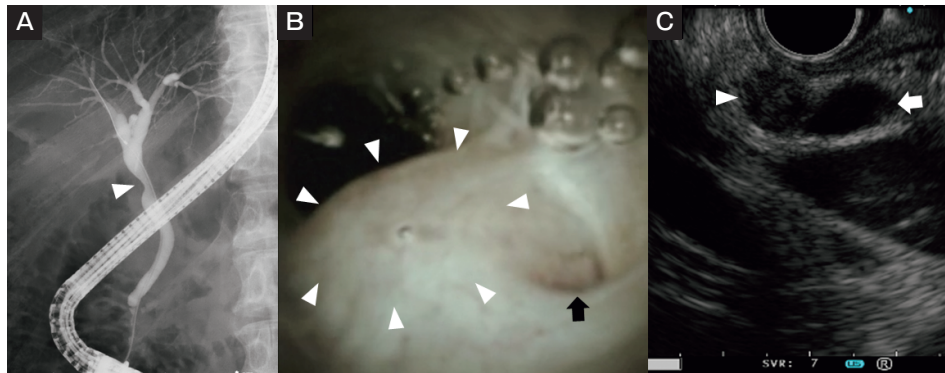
Cholangiopancreatography, cholangioscopy, and endoscopic ultrasonography results. A, Endoscopic retrograde cholangiopancreatography revealed a hemispherical defect of the bile duct (arrowhead); B, Cholangioscopy revealed an elevated lesion covered with smooth mucosa (arrowhead) near the aperture of the cystic duct (arrow); C, Endoscopic ultrasonography (EUS) revealed the presence of an 8.4-mm hypoechoic nodule (arrowhead) adjacent to the bile duct (arrow).
